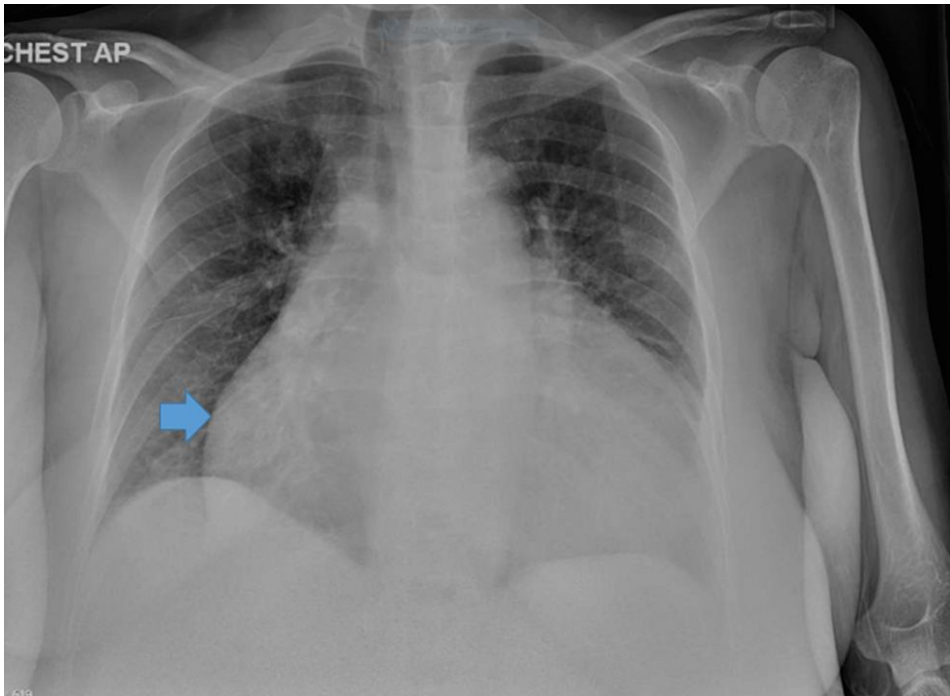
Chest X-ray on admission showing massive cardiomegaly.
